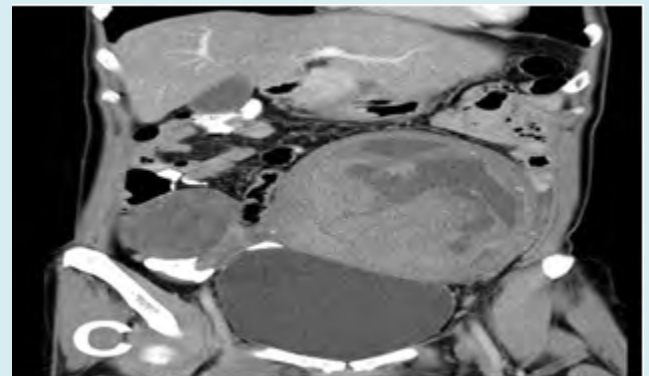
CT abdominal and pelvic with double contrast, coronal view.
